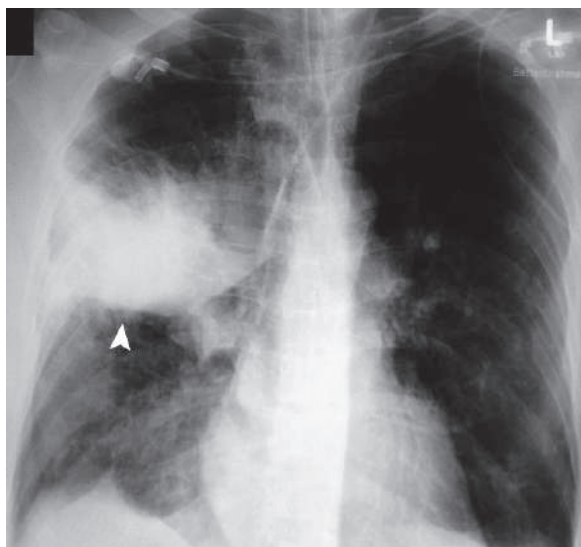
Anteroposterior plain chest radiograph of a bedridden patient shows right upper lobe pneumonia with bulging of the transverse fissure (*arrowhead*)
